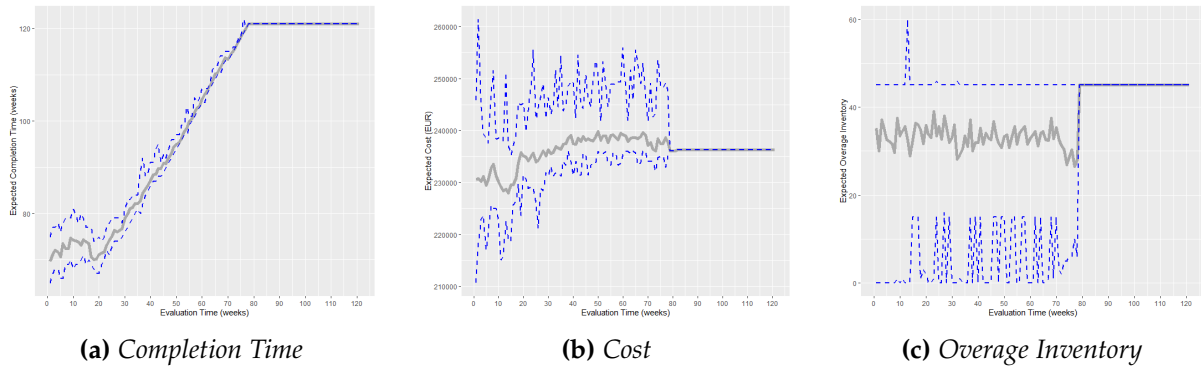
Evolution of estimations for key indicators of CT BO29389 using the S40K10 model
